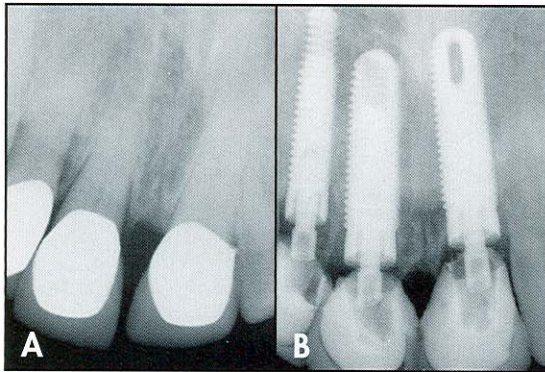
Preoperative periapical radiograph. 15B. Immediate postoperative radiograph of the seated implants.
